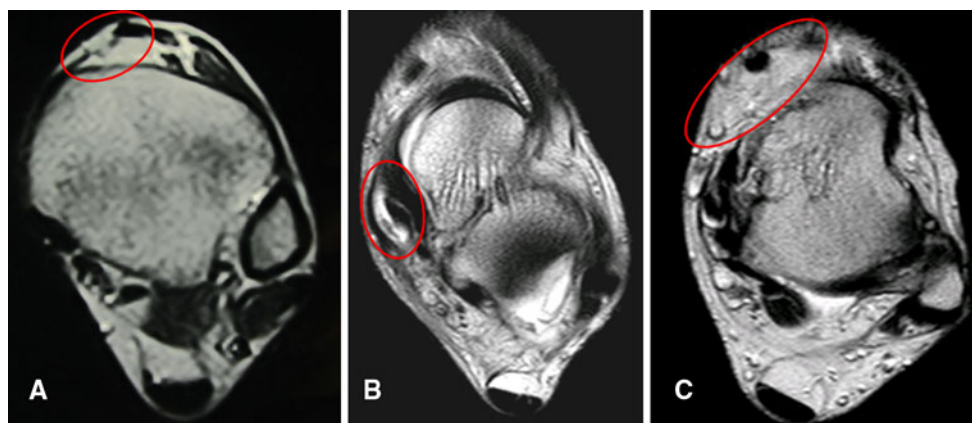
MRI visualization of various types of ankle retinacula alterations. a Evident full-thickness gap of one retinaculum. b Edema around retinaculum. c Adhesion of retinaculum and subcutaneous tissue (leading to poor identification of retinaculum)
